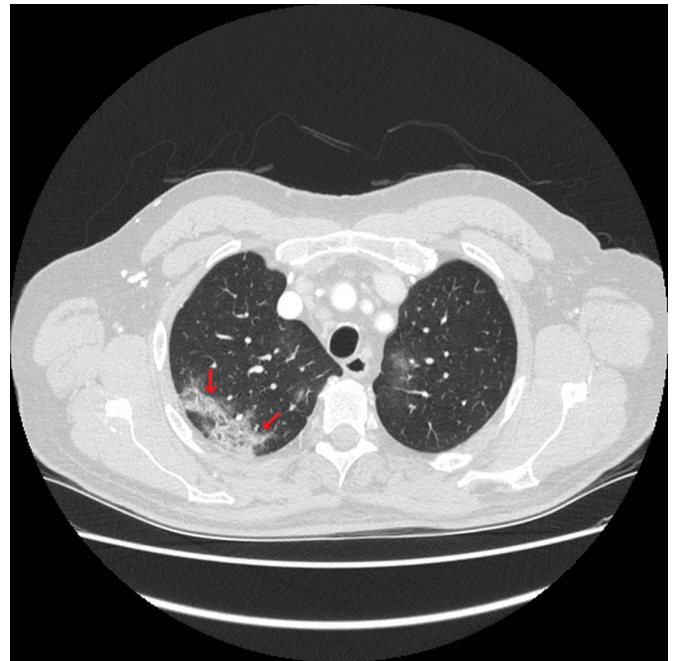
CT scan in axial plane showing streaky consolidations in the right upper lobe (arrows).
